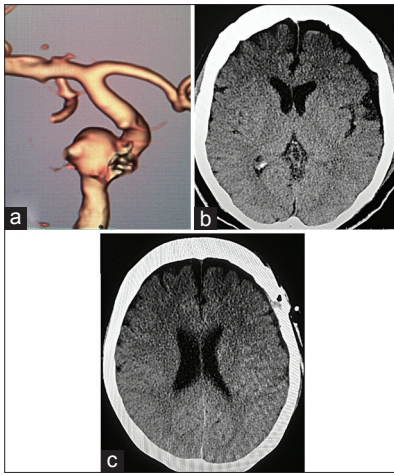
(a) Three-dimensional computed tomography angiography image of right internal carotid artery-posterior communicating aneurysm, (b) postoperative right internal carotid artery-posterior communicating aneurysm clipping with almost nil dead space and no pneumocephalus, (c) follow up computed tomography head at 3 months with no chronic subdural hematoma/hygroma formation
